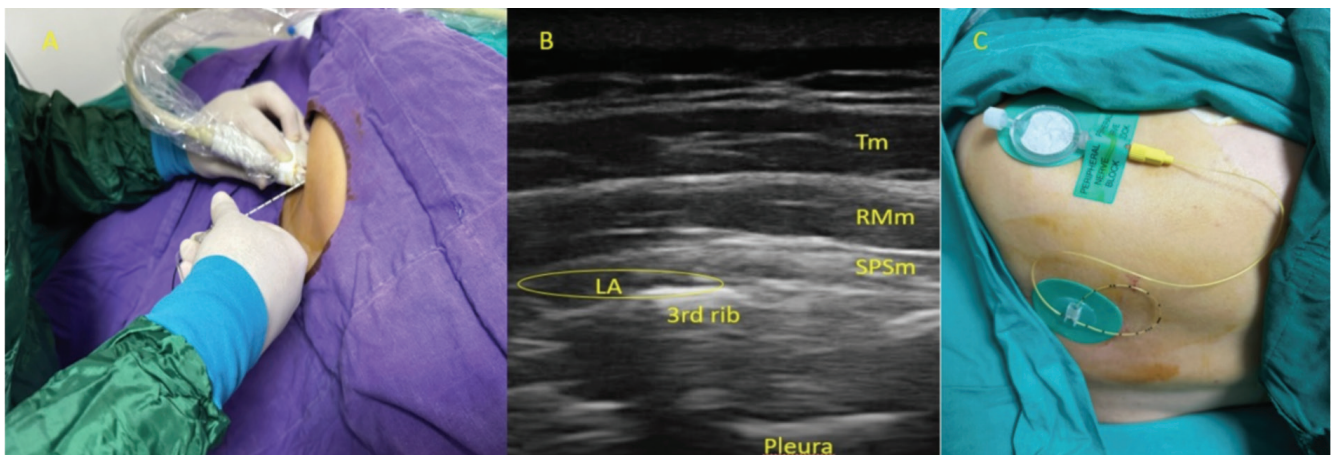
Placement of the SPSIPB catheter (A) Patient position and probe placement, (B) ultrasound anatomy during the block, (C) the catheter fixed at the injection site
